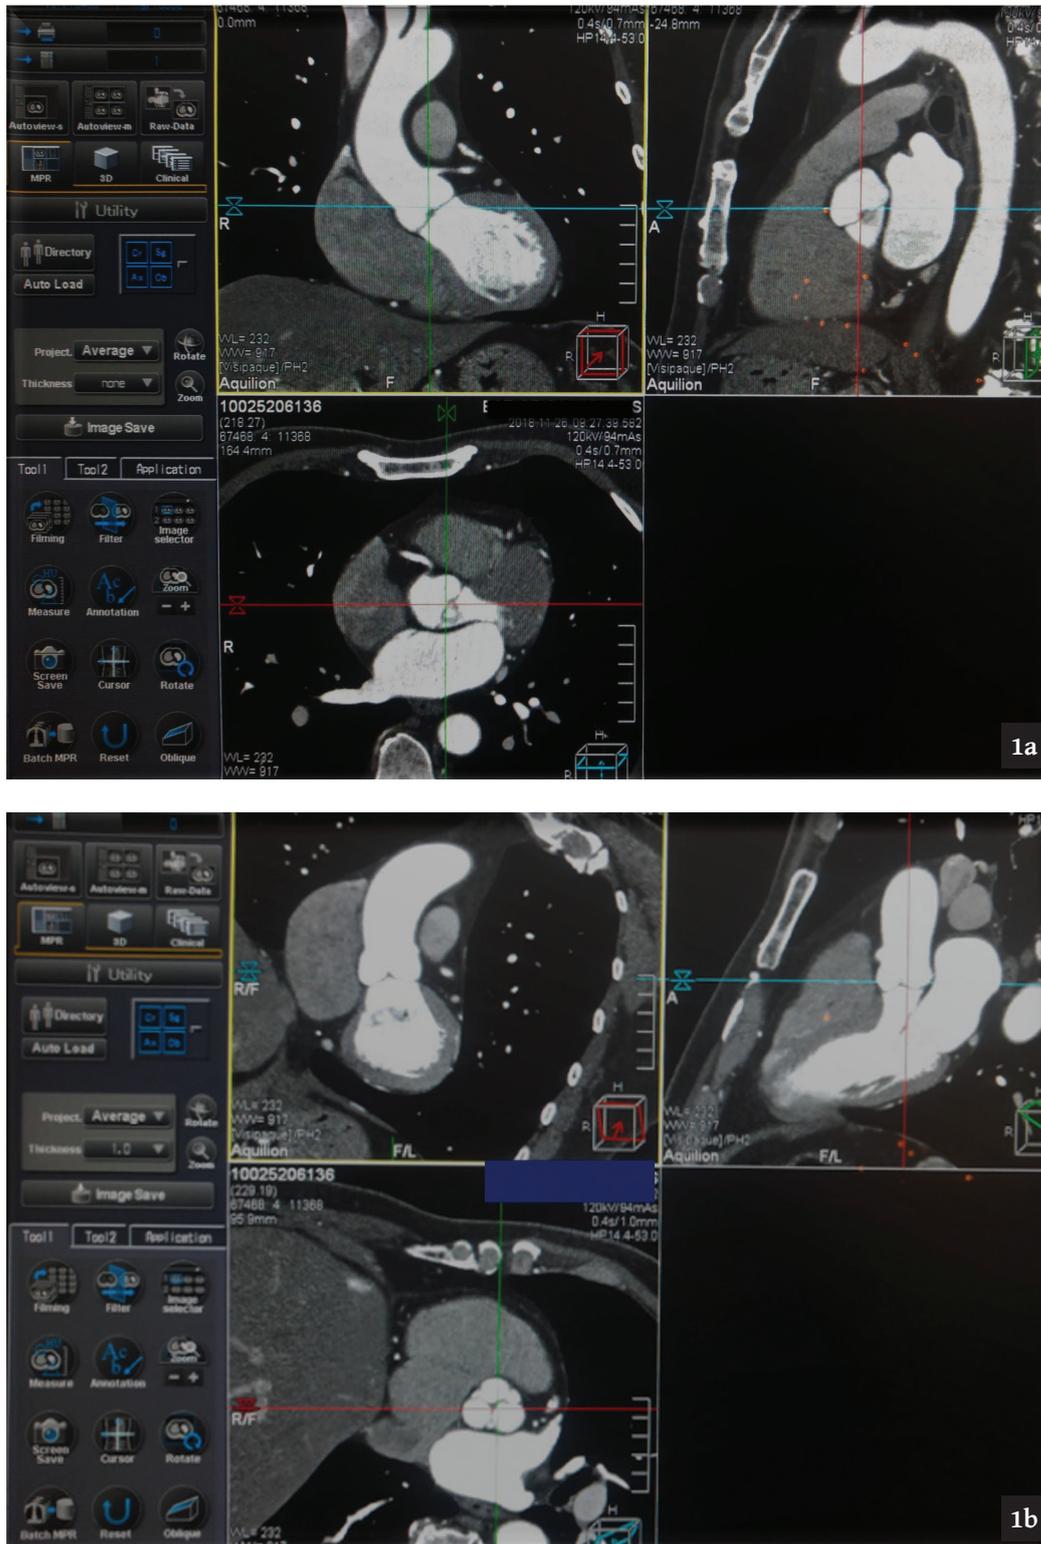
a) The CTA dataset (in systolic phase) as it is loaded on the workstation. The original three imaging planes are orthogonal to each other at a 90° angle and the reference lines are located on the center of the aortic valve. b) the three imaging planes after reformation to the annular plane: the derived axial image shows the three valvular leaflets, which are symmetric.
